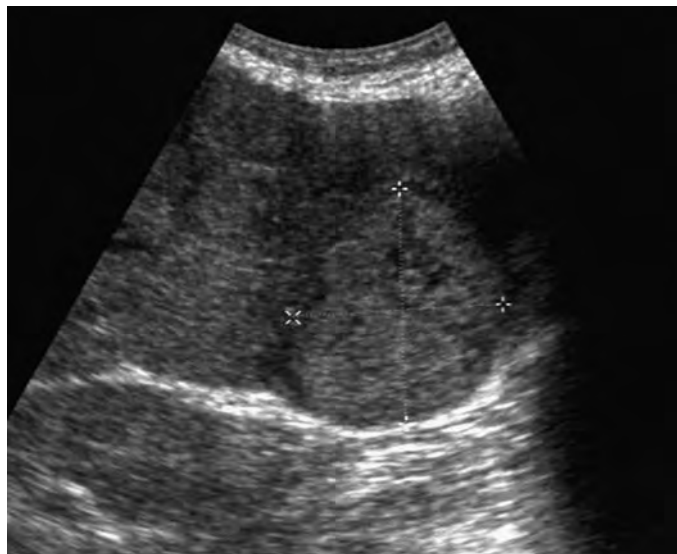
Adenoma: ultrasound findings. There is a large, solid echogenic mass in the right lobe of the liver. Note the fairly well defined hypoechoic rim.
